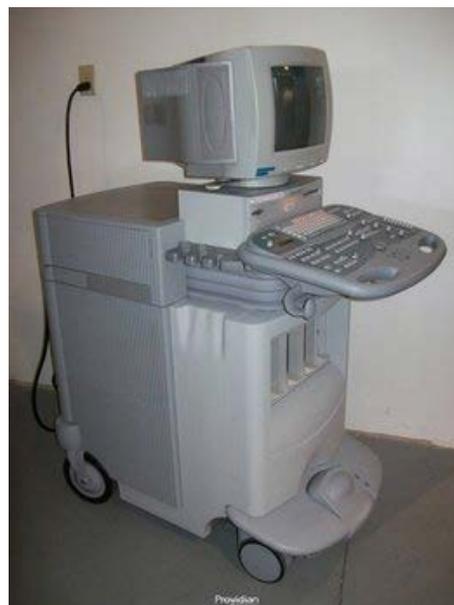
"Old" ultrasound system. Note the massive size, rendering transport relatively difficult and the "old style" monitor that can be only minimally moved.
